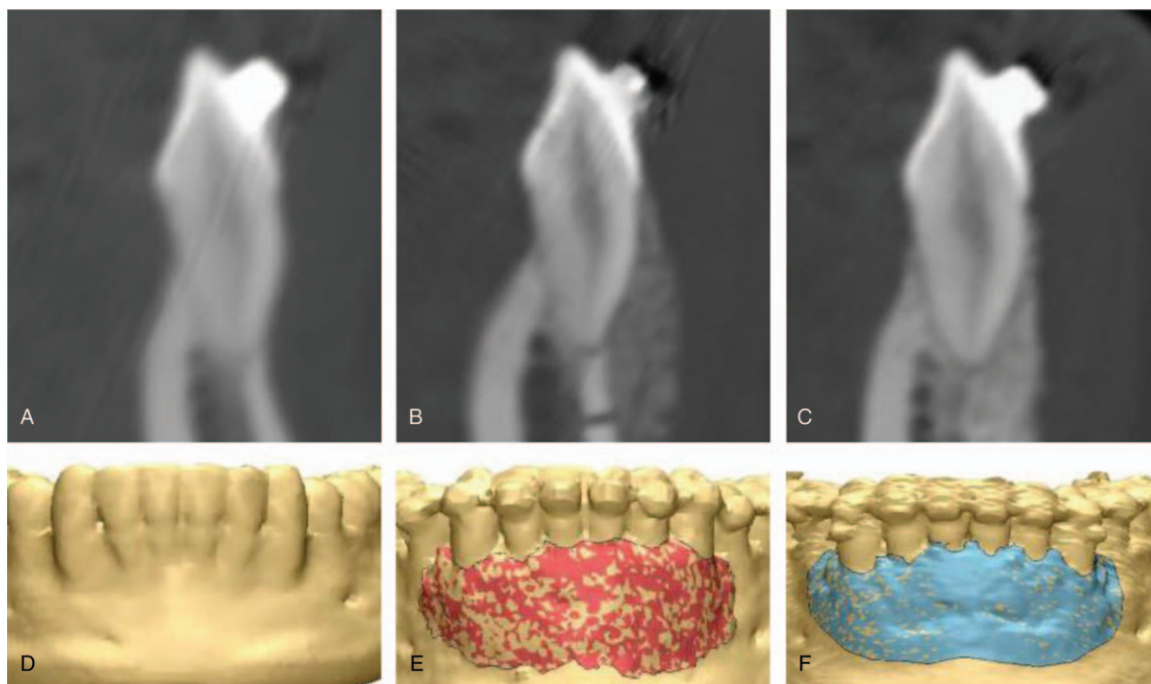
Cone-beam computed tomography images and image-based 3-dimensional reconstruction. Bone defect on the labial cortical bone at baseline (A, D) and increased alveolar volume during 6-month (B, E) and 12-month follow ups (C, F), respectively.
